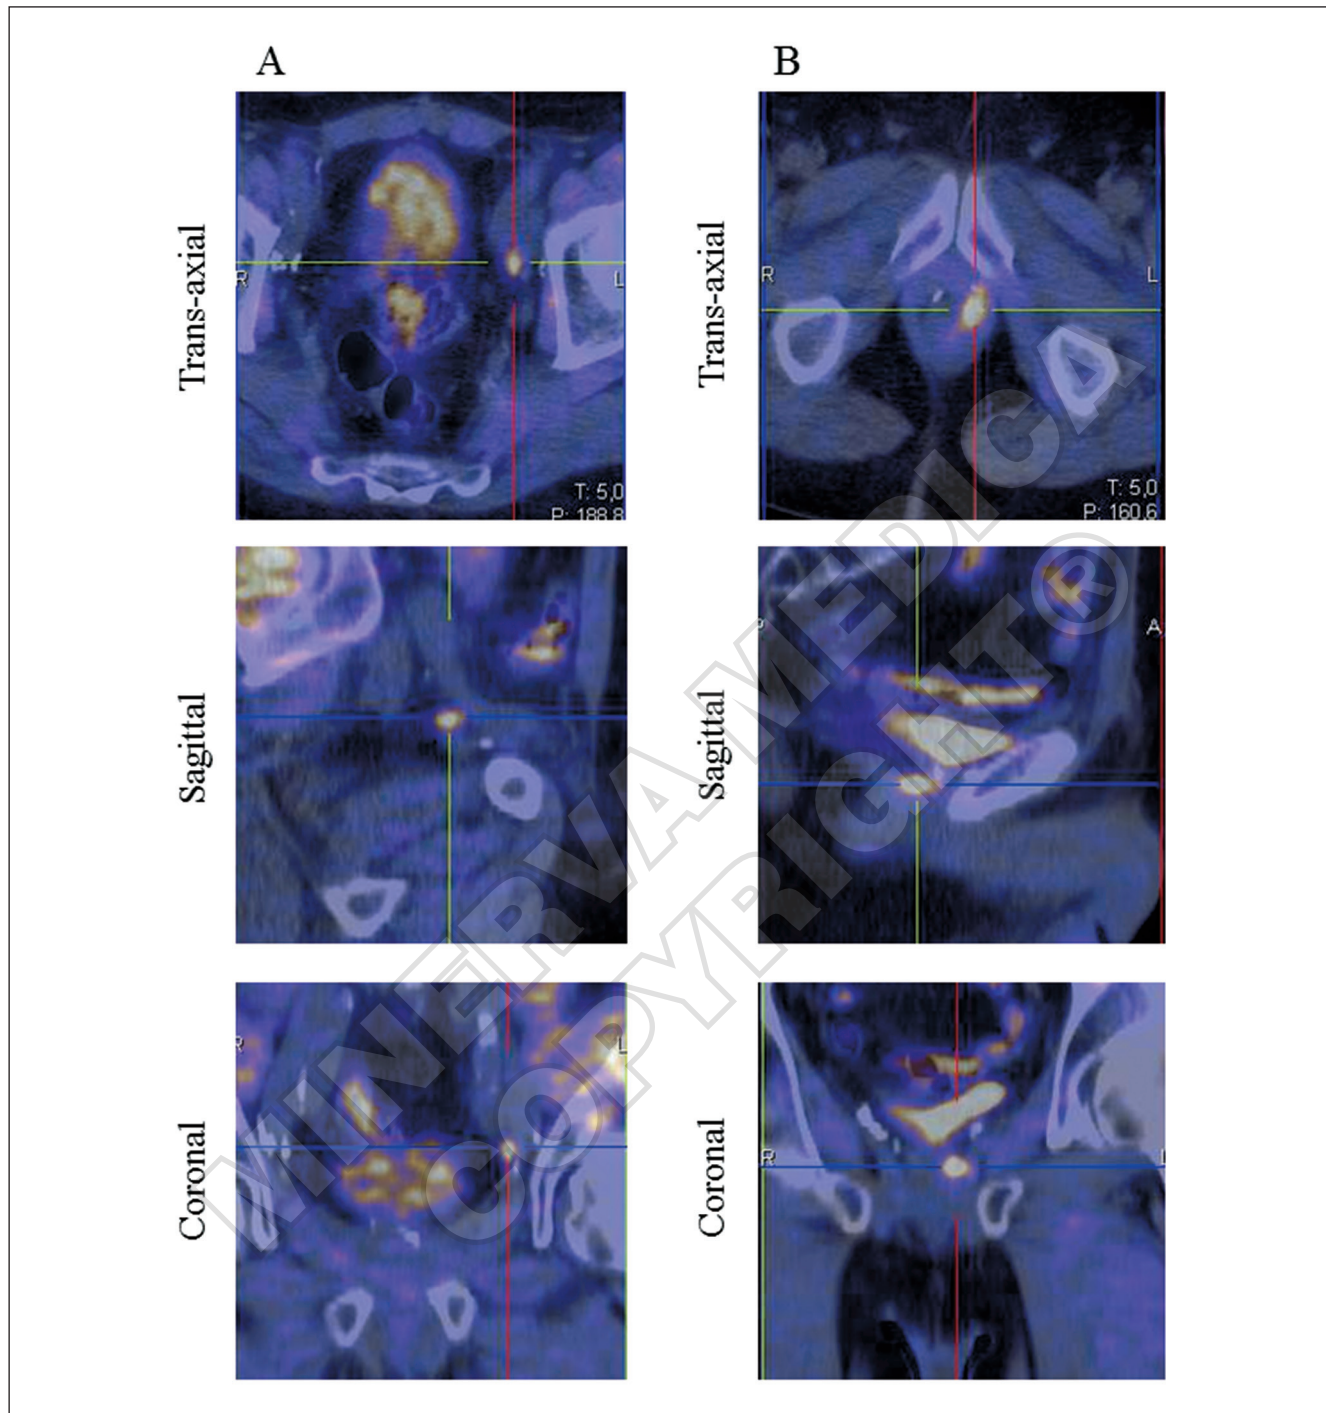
A) 75-year old man with a prostate cancer (radical prostatectomy in 2008) who showed an increase of PSA levels (0.27 ng/mL in October 2014 and 0.54 ng/mL in February 2015). PET/CT with 18F-Choline PET/CT performed at the end of February 2015 showed a focal uptake in left internal iliac lymph node (size: 0.8 mm). B) A 65-year old man with a slight increase in PSA after 6 months from radical prostatectomy (March 2012). The patient was sent to 18F-Choline PET/CT in December 2012 that detected the presence of local prostatic fossae recurrence with a PSA level=0.82 ng/mL.
